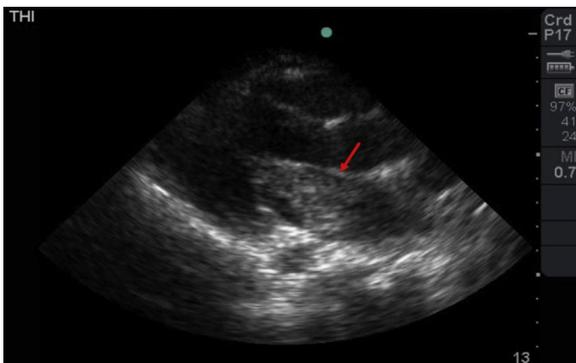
Parasternal long axis view showing a large mass in the left atria.
